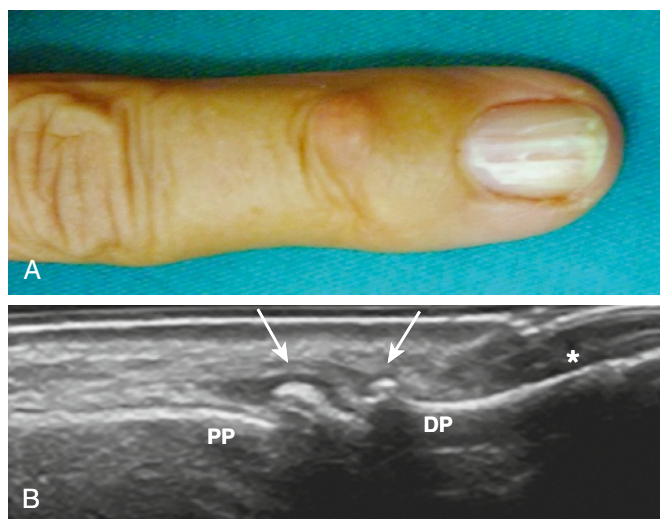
A, Ultrasound is used to assess a hand with Heberden's node of the second finger. B, The 15-MHz longitudinal scan over the superior aspect of the second distal interphalangeal joint (B) shows osteophytes (*arrows*) and a nail (*star*). DP, distal phalanx; PP, proximal phalanx.
